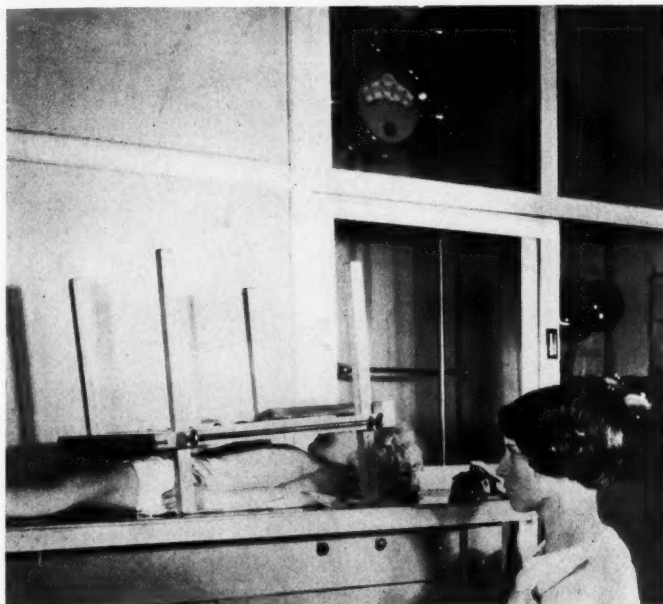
No practical precision apparatus is available at this time for producing radiographs at complete inspiration in infants. The tangential position of the technician's eyes enhances the results.
